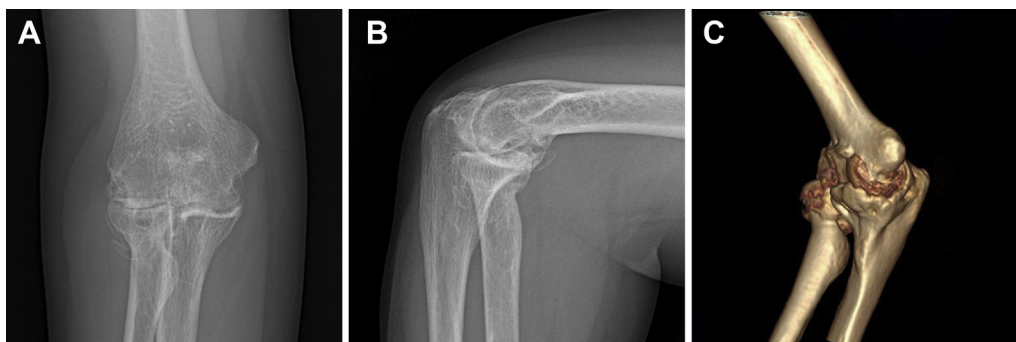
Preoperative imaging examinations were used to evaluate the elbow osteoarthritis. (A) Anteroposterior radiograph, (B) lateral radiograph, (C) 3-dimensional computed tomographic scan.
